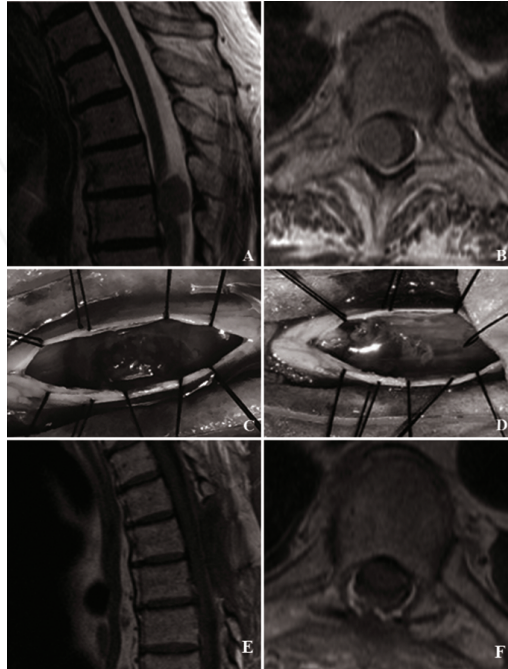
A. Sagittal T2w and B. Axial T1w gadolinium enhanced images of a thoracic spinal meningioma causing spinal cord dislocation. C. Intraoperative pre- and D. post- total resection of the lesion. Dura mater was extensively coagulated with no remnant of the disease, realizing a Simpson Grade of Resection II. E. Sagittal and F. Axial T1w gadolinium enhanced postoperative MRI demonstrating complete resection of the tumor and spinal cord decompression.
